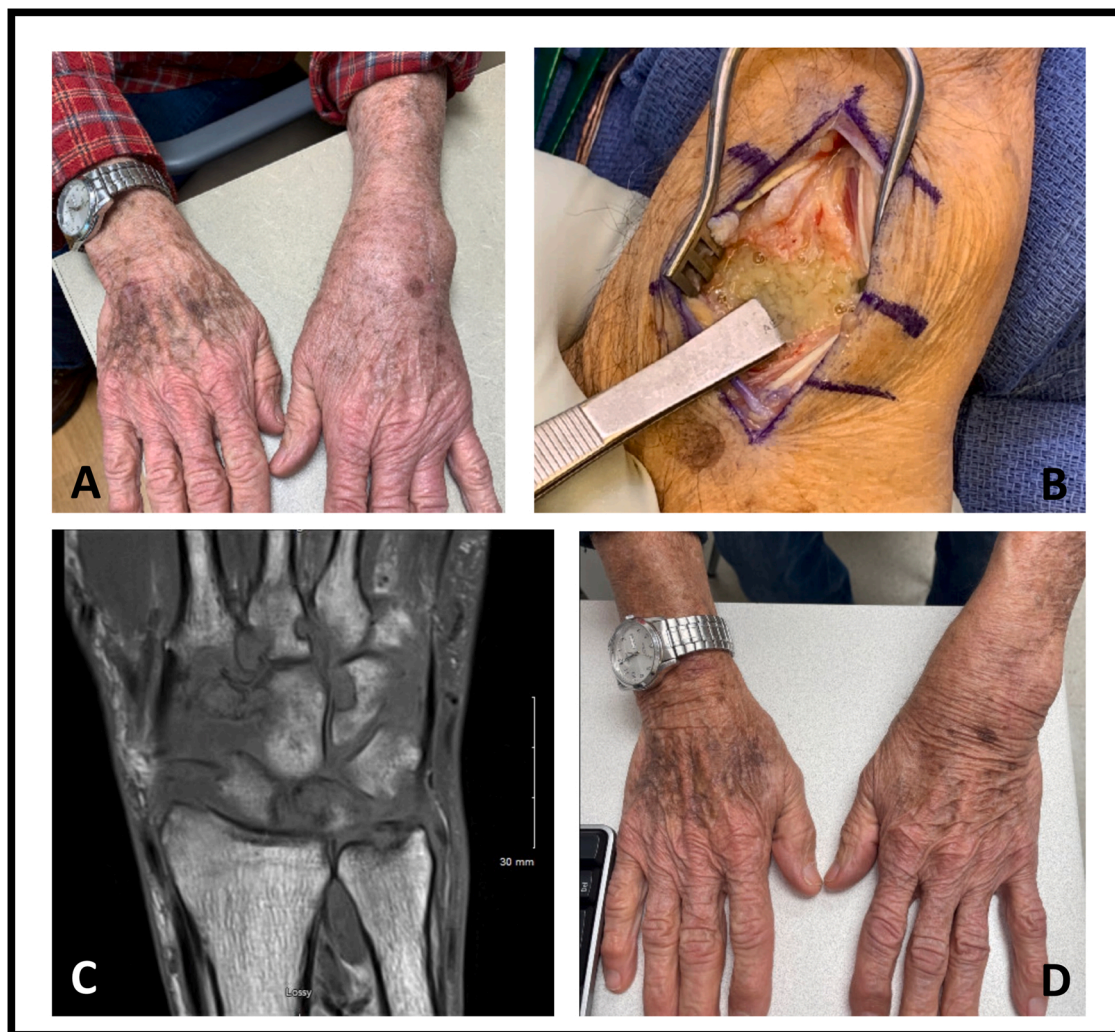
Mycobacterium avium* complex (MAC) infection of left wrist. (A) Pre-operative findings of circumferential left wrist swelling. (B) Intra-operative findings of caseous exudate and synovial inflammation. (C) MRI with pan-carpal erosions, inflammation, and extensive synovitis. (D) Six months post-operative findings, improvement but persistence of swelling off therapy.
